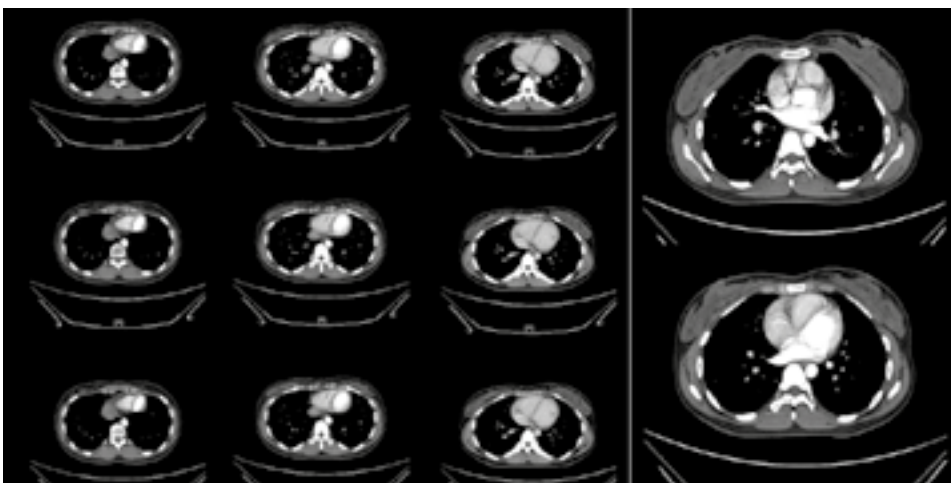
Chest CT scan after bisphosphonate therapy
